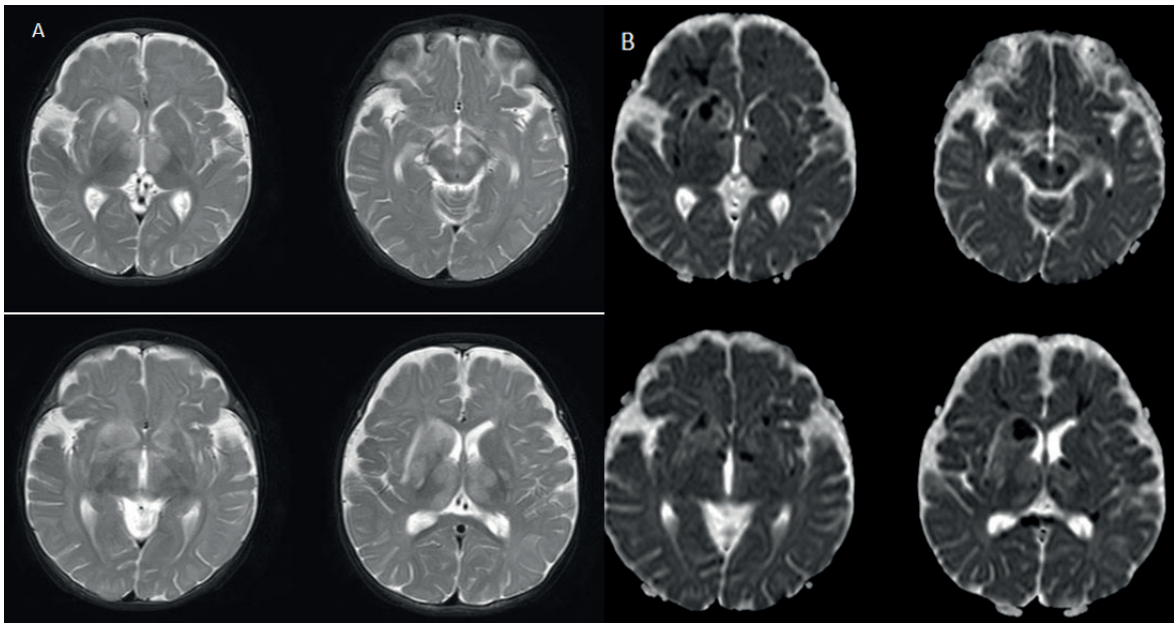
T2-weighted cranial magnetic resonance images show hyperintense pathologic signal changes in bilateral lentiform and caudate nucleus as well as in bilateral thalamus, red nucleus, lemniscus medialis and external capsule. 2B. Corresponding ADC (Apparent Diffusion Coefficient) maps demonstrate restricted diffusion in hyperintense areas suggesting acute ischemic foci.
